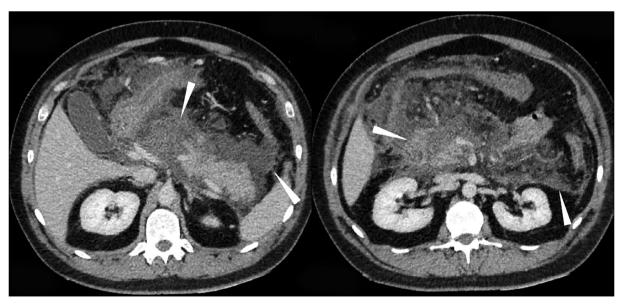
Computed tomography of the abdominal organs with intravenous contrasting: infiltration and fluid accumulations in the peripancreatic fatty tissue, along the perirenal fascia on the left, in the parenchyma of the pancreatic head and body (arrows)
